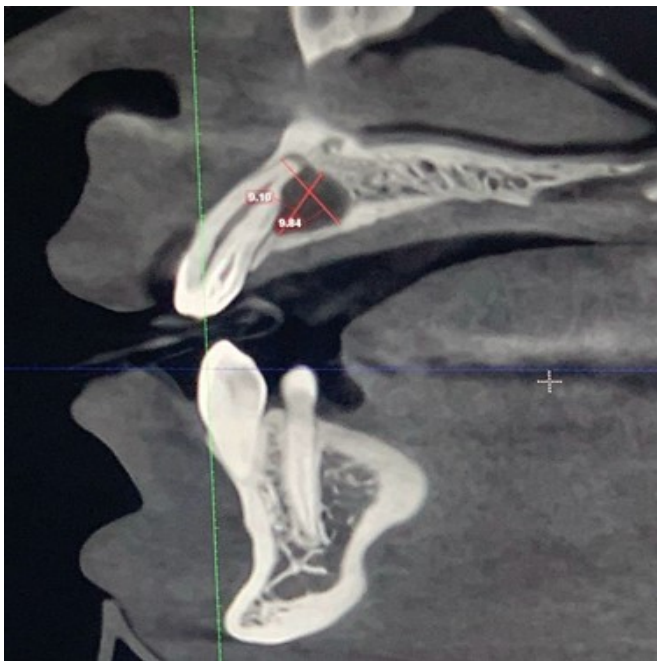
CBCT Sagittal full view and zoomed-in lesion area
